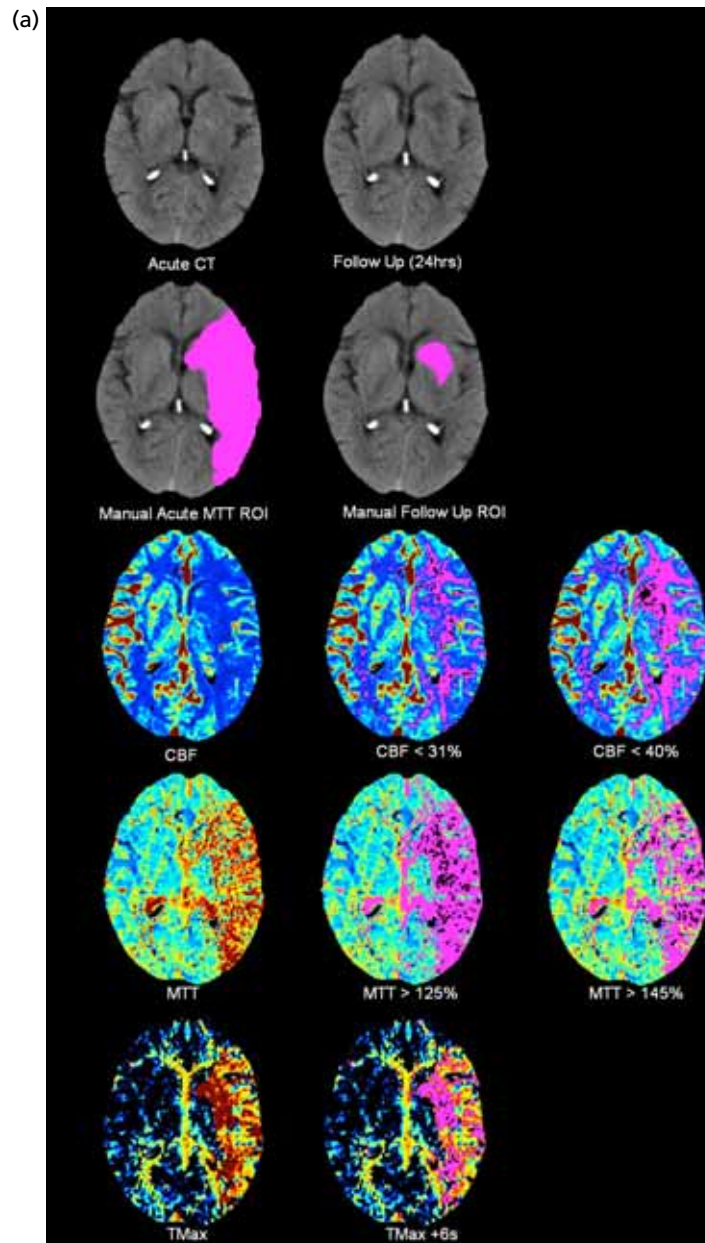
Example of CT perfusion parameter maps. (a) CT with plain structural image at randomisation and post randomisation, with infarct outlined, perfusion maps and various thresholds below; (b) MR with acute DW1 and T2, follow-up T2, perfusion maps and various thresholds below. ROI, region of interest. (*continued*)
